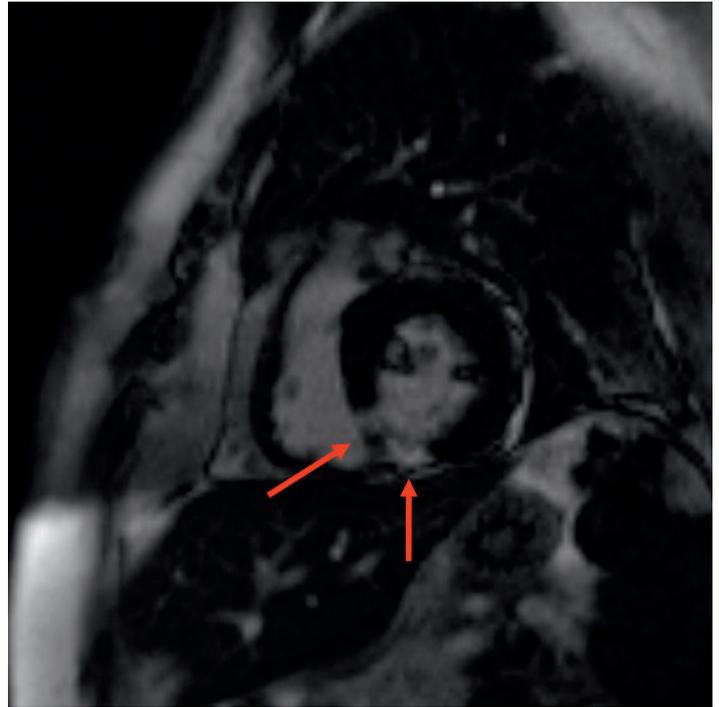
Two-chamber view SSFP MR image (TR: 39.6, TE: 1.12, flip angle: 74°, FOV: 276 x 340) demonstrates the lateral left ventricular wall irregular hypointense lesion representing metastasis (yellow arrows). SSFP: steady state free precession; MR: magnetic resonance; TR: repetition time; TE: echo time; FOV: field of view.
